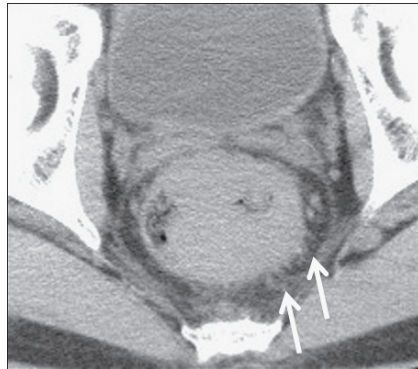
Axial CT scan of rectal cancer. The mass involves nearly the entire circumference of the rectal wall. Note the strands of soft tissue extending to the peri-rectal fat (arrows), suggesting transmural extension of tumor. At surgery, this was, in fact, proven to represent tumor extending beyond the rectal wall (T3 disease)
